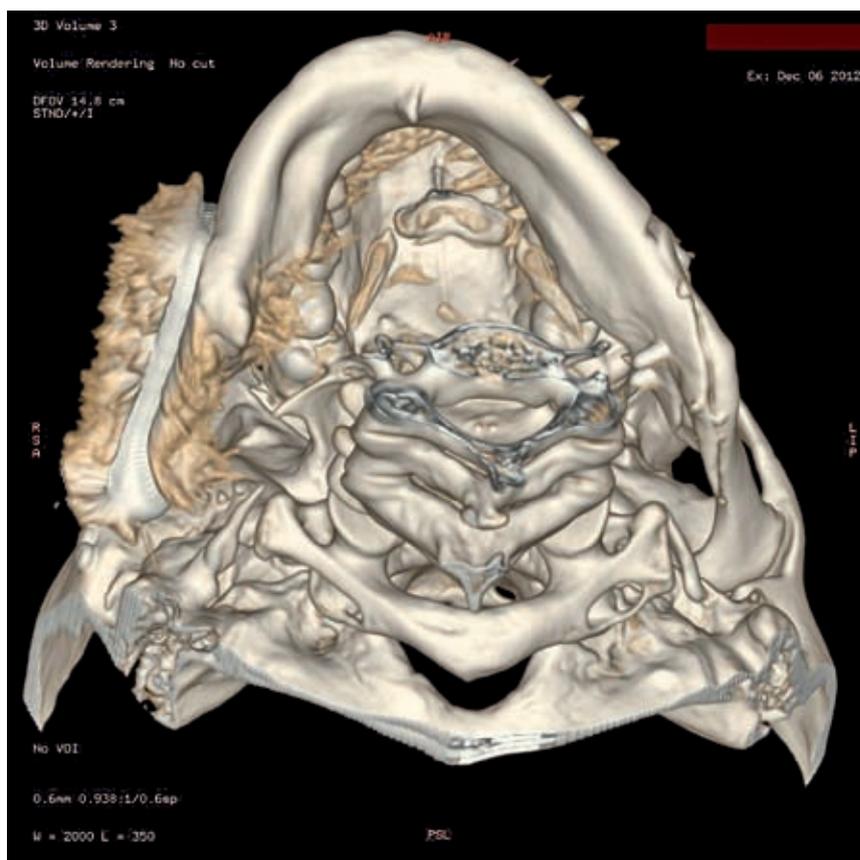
CT of patient's head after implantation of prosthetic TMJ, bottom view of the mandible
